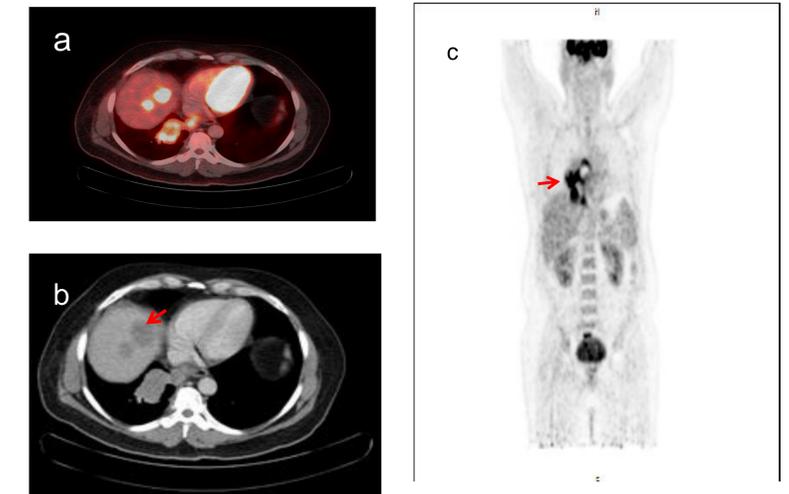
Re-staging scan of a 53 year old male with hepatocellular Carcinoma after liver transplantation, showing disease recurrence with avid hepatic hypodensities and right peri-bronchial lymph nodes, shown on fused axial (a), CT only axial (b) and PET only (c) images.
